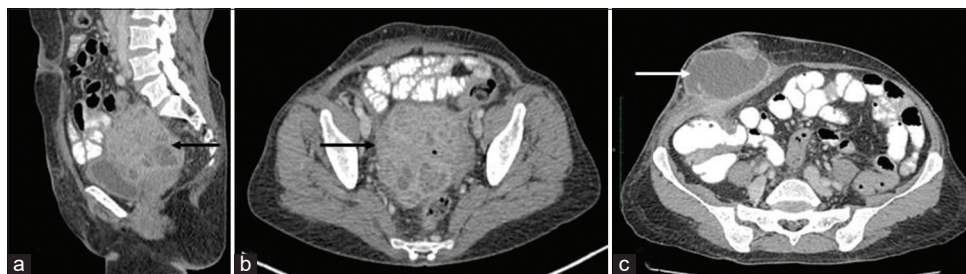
Contrast-enhanced (a) sagittal (b and c) and axial CT sections of pelvis show a bulky uterus, multiple intramural lesions (black arrows) with serosal irregularity with a peripherally enhancing collection (white arrow) in the right anterolateral abdominal wall with surrounding inflammatory changes.
